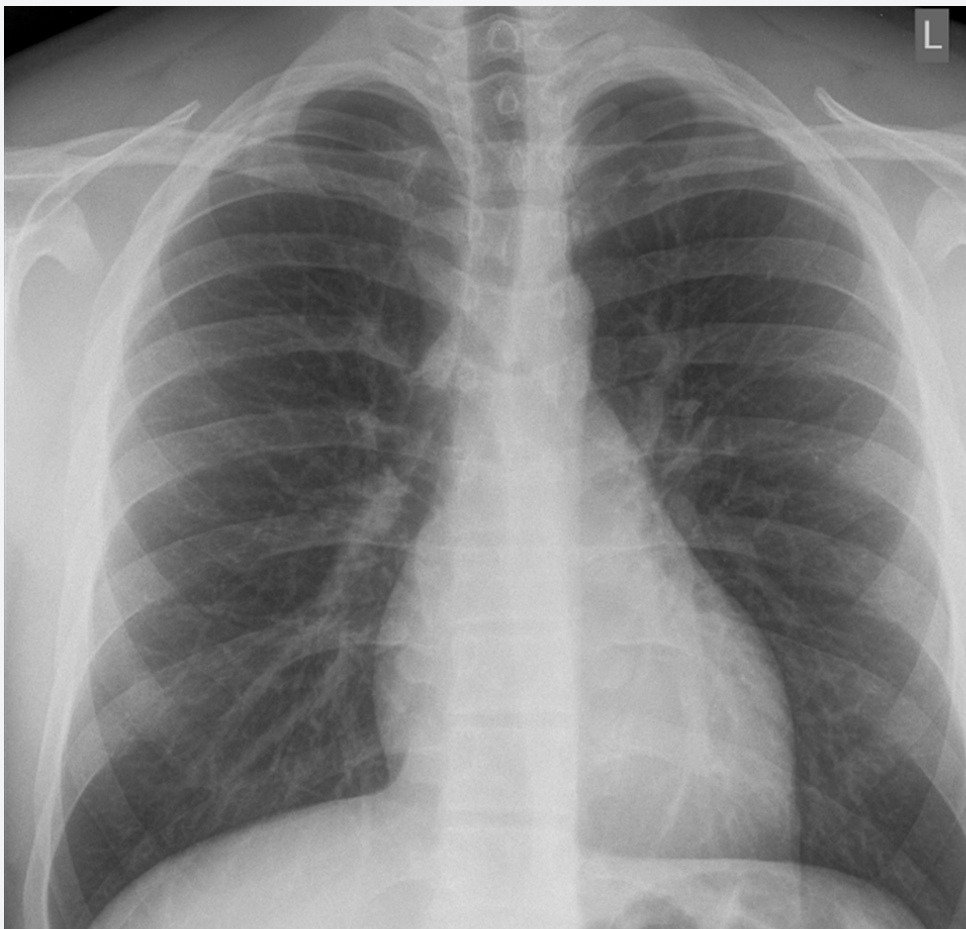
Conventional chest X-ray shows no reduction in transparency; no typical finding of COVID-19 pneumonia was detected.
